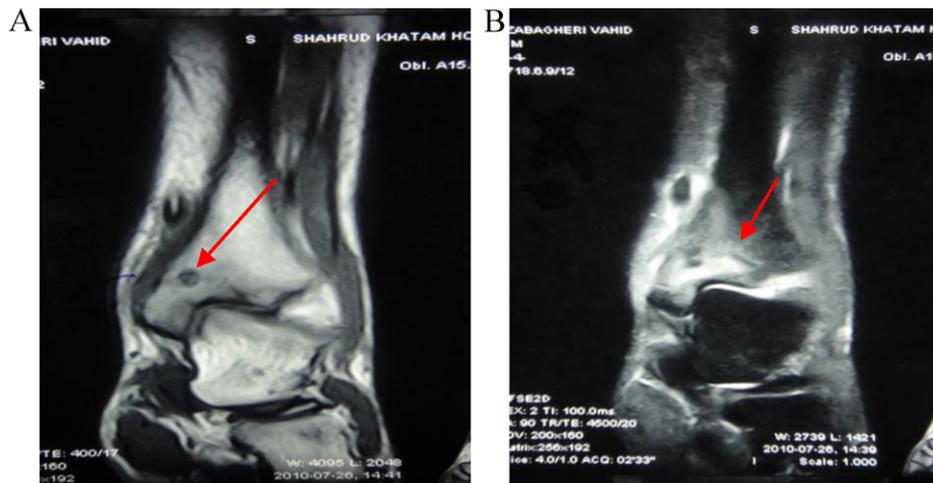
(A) Coronal T1 weighted MRI showing hypointense nidus (Red arrow). (B) Coronal T2 weighed MRI showing bone marrow edema around a nidus (Red arrow).
